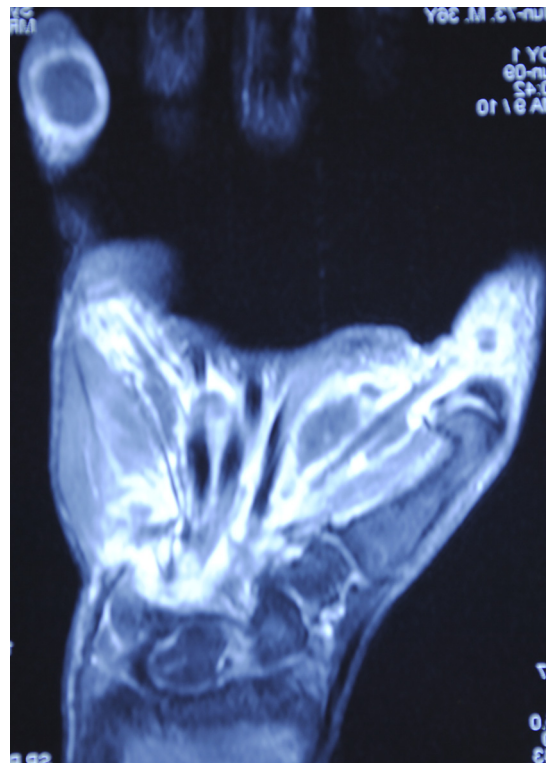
The coronal image of the hand and wrist shows hyperintense signal in the pulp of the small finger and in the wrist near the flexor tendons at the carpal region which is consistent with inflammation on T2-weighted image.
